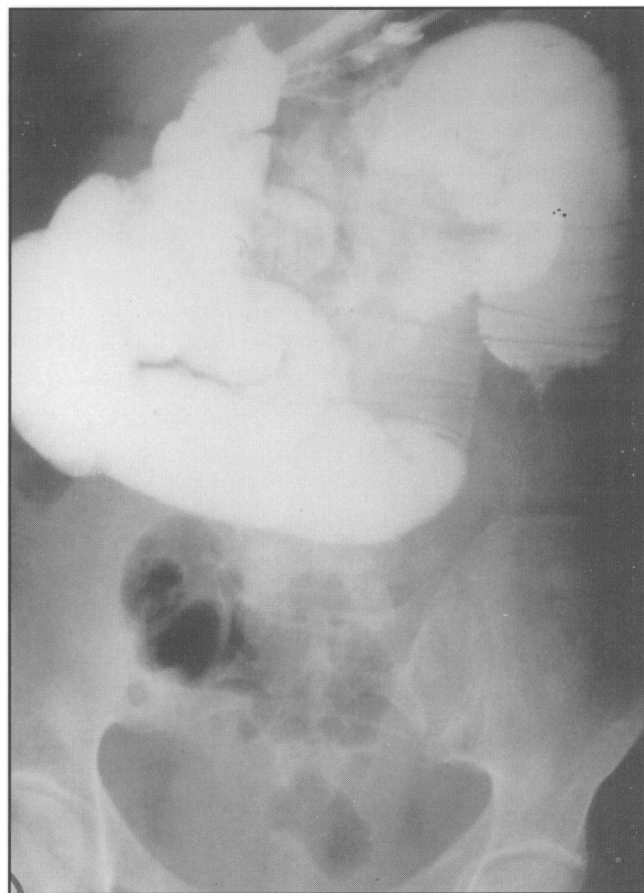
This radiograph shows an obstruction in the mid ileum and the blunted appearance at the site of the obstruction is typical of an intussusception.
